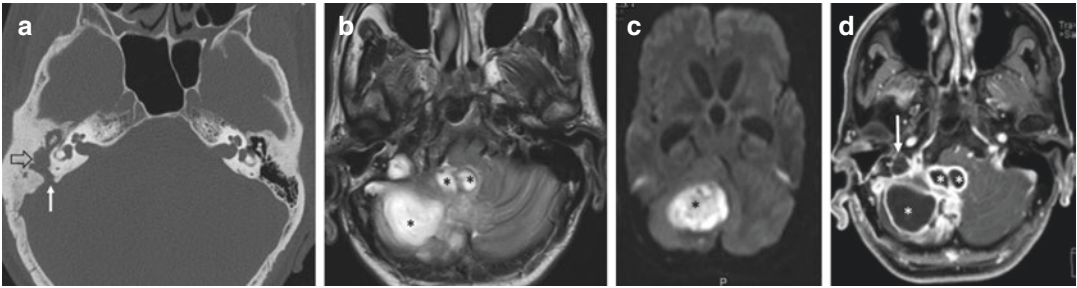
(a) Axial HRCT, (b) Axial T2-WI MRI, (c) Axial DWI MRI, and (d) Axial Contrast enhanced T1-WI MRI. (a) Showing CT features of right sided otomastoiditis/cholesteatoma (black empty arrow) with focal bony erosion along the posterior wall (white arrow). (b)
